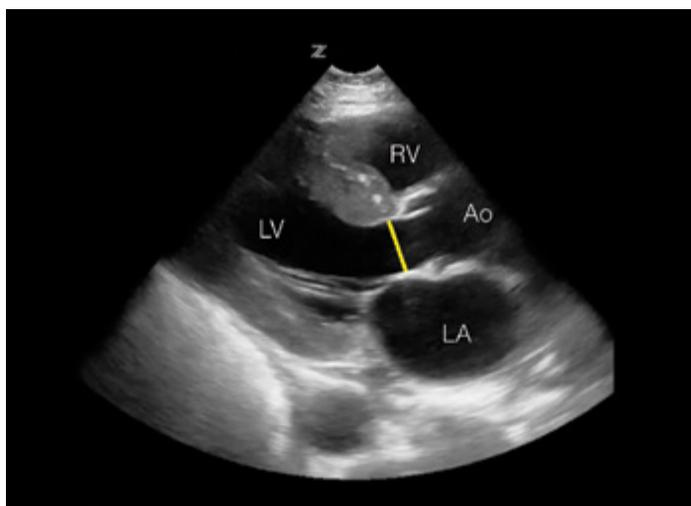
Image of parasternal long view with highlighted LVOT
